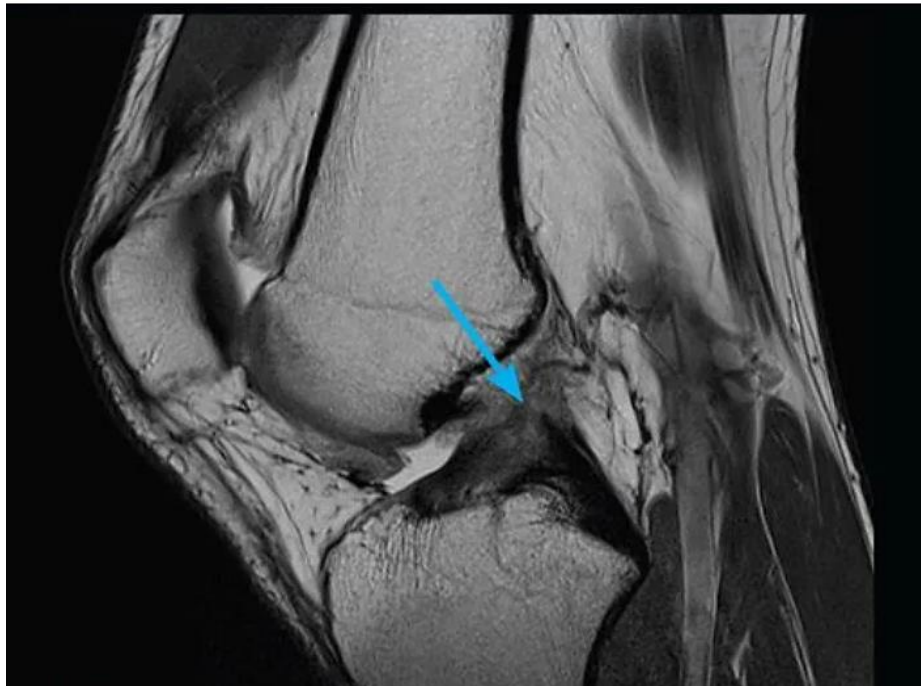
Sagittal MRI of the knee in a patient presenting with instability following a twisting injury demonstrates mid substance rupture of the anterior cruciate ligament (arrow).
